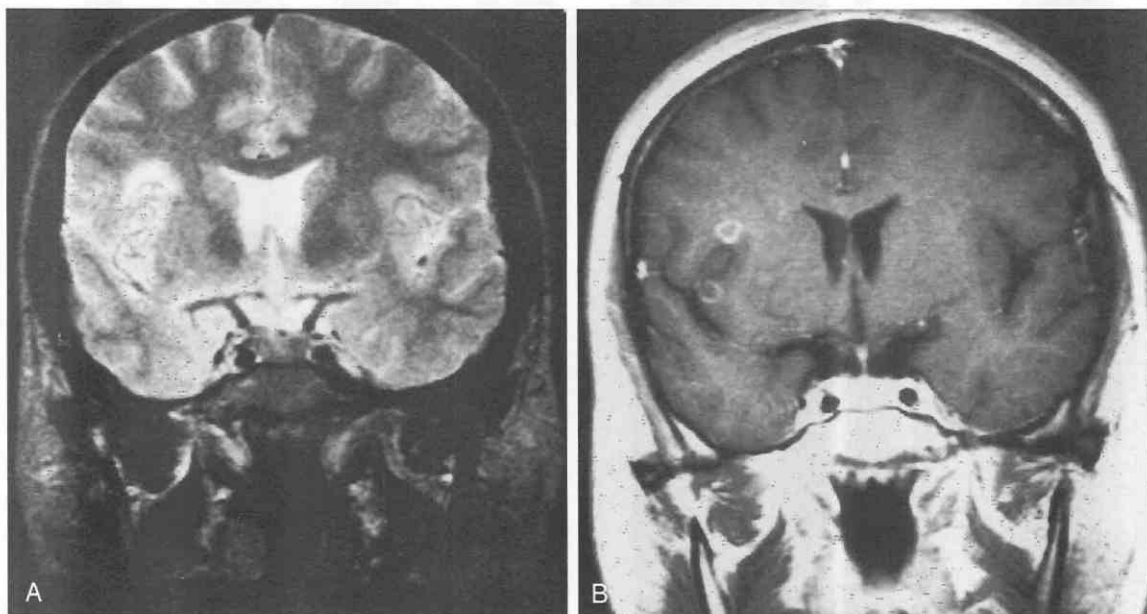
Parenchymal cysticercosis. *A*, T2-weighted image shows no definite abnormality. *B*, Gadolinium-enhanced image shows two ringlike enhancing lesions in the right insular cortex.
